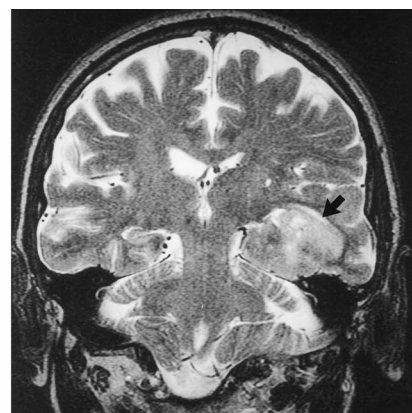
Coronal T2-weighted image (4000/105/1) shows a left-sided posterior temporal tumor (arrow). Also evident is the larger right lateral ventricle and apparent thinning of the right fornix, which are unrelated to the tumor.
